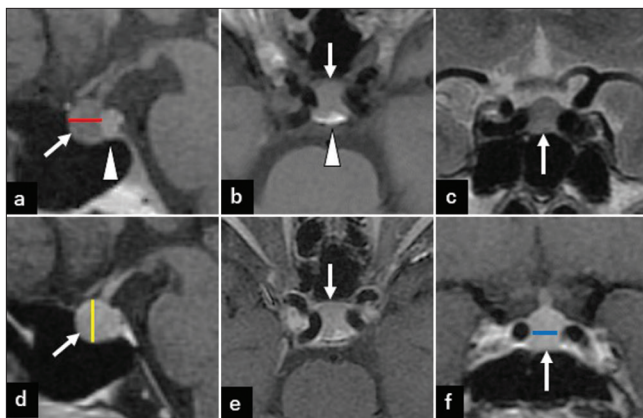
Magnetic resonance imaging of the pituitary mass at 61 years old. (a) T1-weighted (W) sagittal image. (b) T1W axial image. (c) T2W coronal image. (d) Gadolinium-enhanced (GE) sagittal image. (e) GE axial image. (f) GE coronal image. Red bar in 1a: Antero-posterior diameter, Yellow bar in 1d: Height, Blue bar: Transverse diameter at mid-intercarotid level. A pituitary mass (arrow, in a-c) with similar intensity to the brain parenchyma existed in front of the posterior pituitary lobe (arrowhead in a and b). The gadolinium moderately and diffusely enhanced the pituitary mass (arrow, in d-f).
